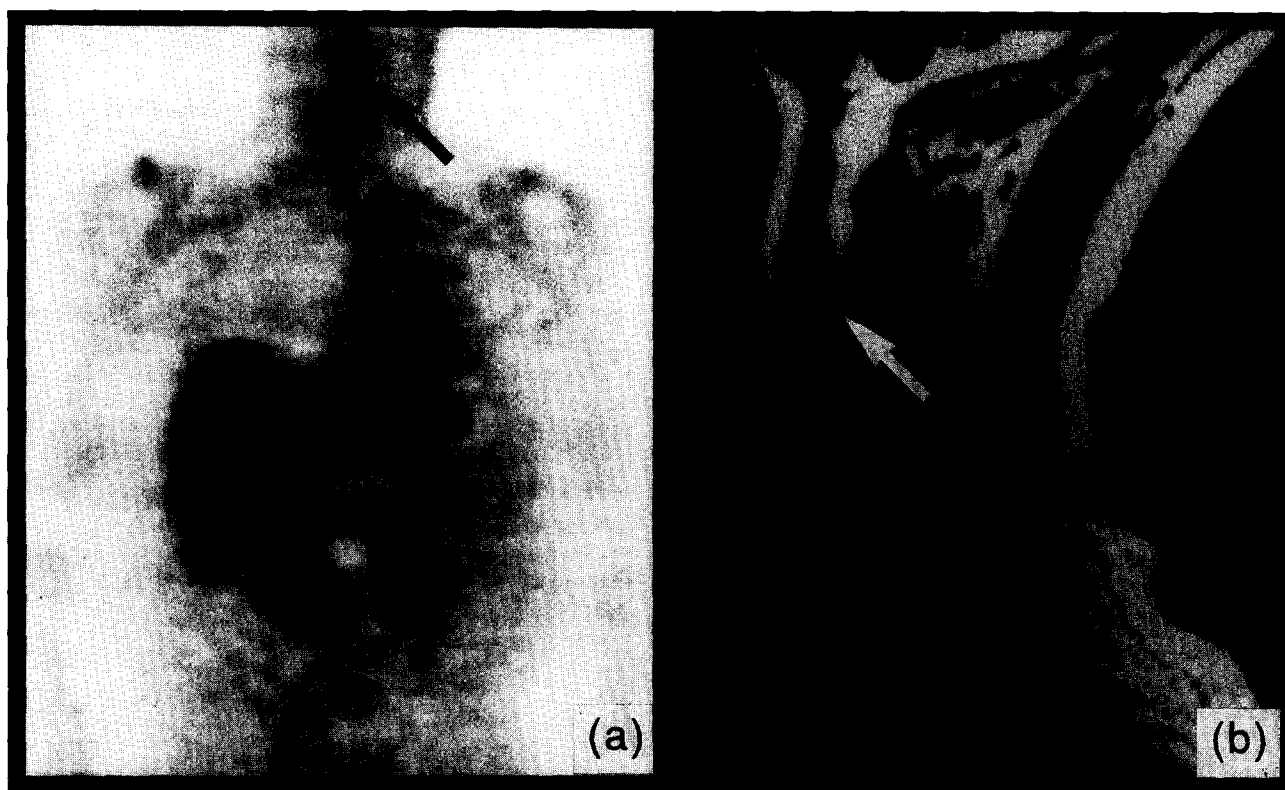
(a) Coronal FDG PET image showing a metastatic tumour focus in the neck (arrowed), a large cavitating tumour deposit in the liver, and normal bilateral renal concentration of tracer. (b) Sagittal MR image revealing the cervical metastasis to be an intramedullary deposit (arrowed) in the cervical spinal cord.
